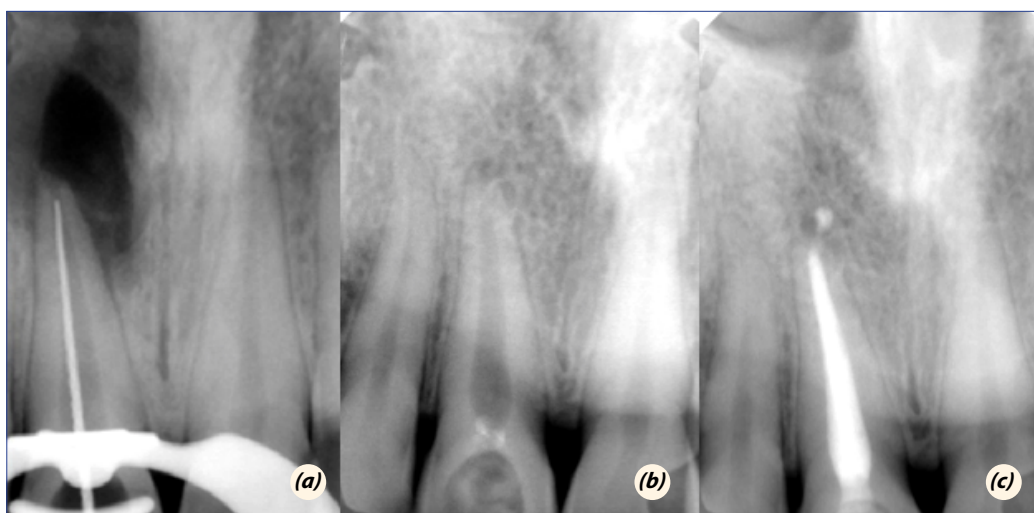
(a) Working length determination radiography - (b) Radiograph with temporary filling after 10 months (c) 1-year follow-up radiograph.
